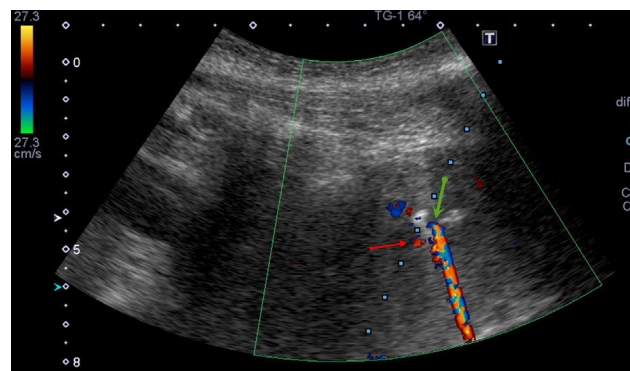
Pulse Doppler ultrasound after deployment of the coil demonstrates decrease in the flow; however, persistent low resistance arterial flow is recorded, suggestive of noncomplete response to coil deployment.
